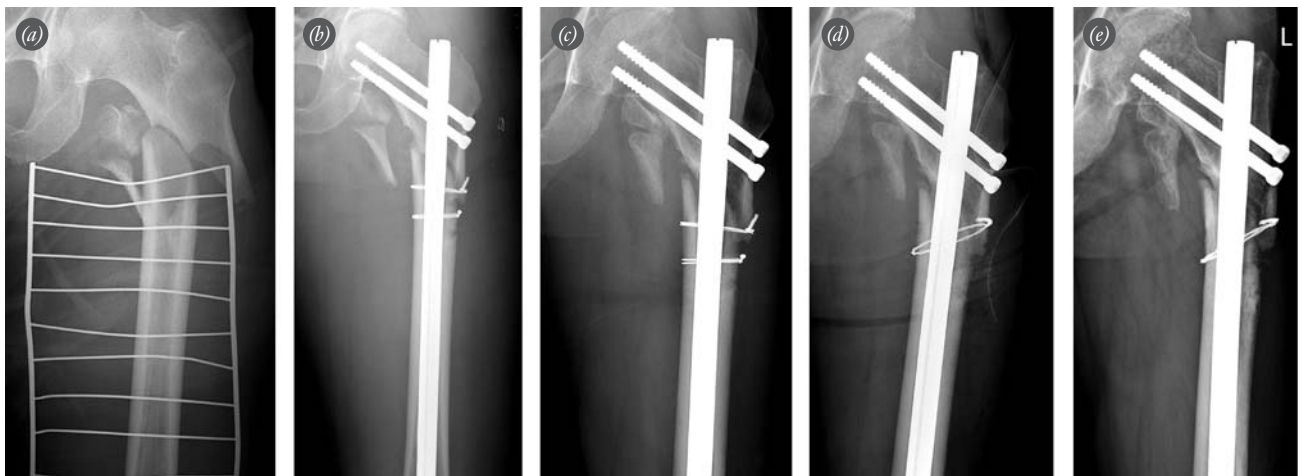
Antero-posterior view of a subtrochanteric fracture (a) in a 70-year-old male patient who fell down the stairs. (b) Open reduction using a reconstruction nail & wire. Radiograph shows an atrophic nonunion (c) six months after the operation. (d) Autogenous bone graft and wiring retaining reconstruction nail. Final radiograph shows a nonunion (e) 8 months after the revision surgery.
